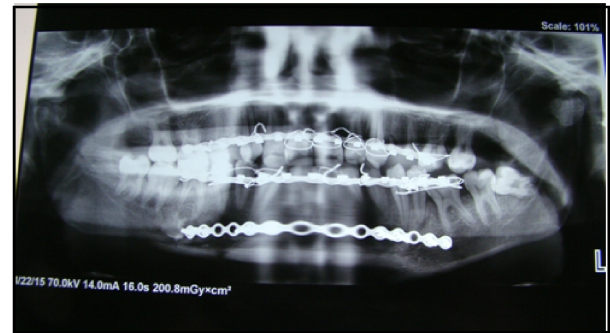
Post operative radiograph showing single plate RT para symphysis mandible with Erich arch bar
